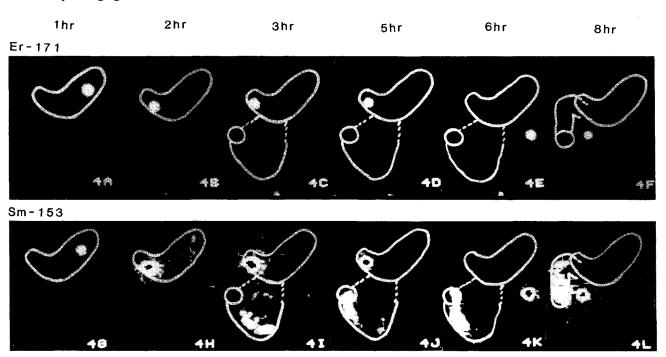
Gastrointestinal transit of the dual-labeled bilayer tablet in non-fasted subject number two. Figs. 4A-F show the non-disintegrating ¹⁷¹Er tablet half and figs. 4G-L represent the ¹⁵³Sm labeled portion which was designed to erode slowly. Refer to the text for a description of the scintigraphic images.
